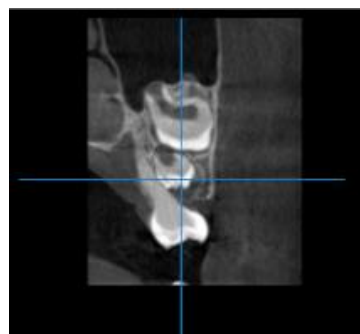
CBCT image – coronal section
